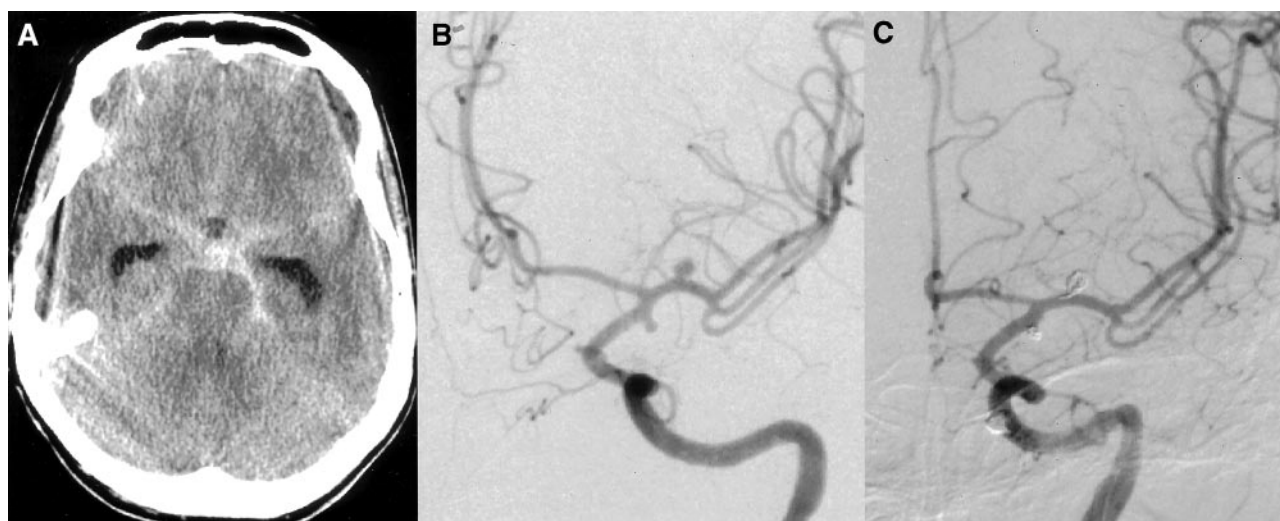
CT on admission (A). SAH Fisher grade 4. Angiograms before (B) and after (C) embolization with platinum coils.
